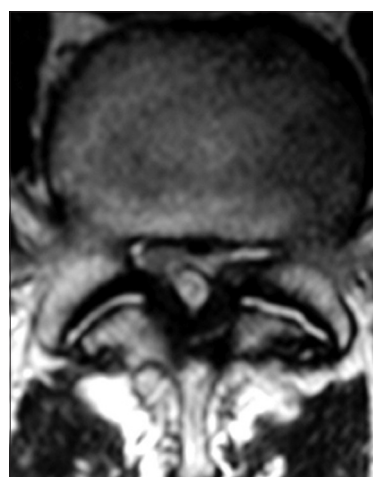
On the axial T1-weighted MR image, congenital lumbar stenosis is exaggerated by the presence of ossification of the yellow ligament (hypointense) resulting in marked bilateral, dorsolateral thecal sac compression. Additionally, fluid is seen in both facet joints, indicating the presence of moderate degenerative changes and instability, accompanied by a broad-based right-sided hyperintense synovial cyst that fills the dorsal aspect of the spinal canal
